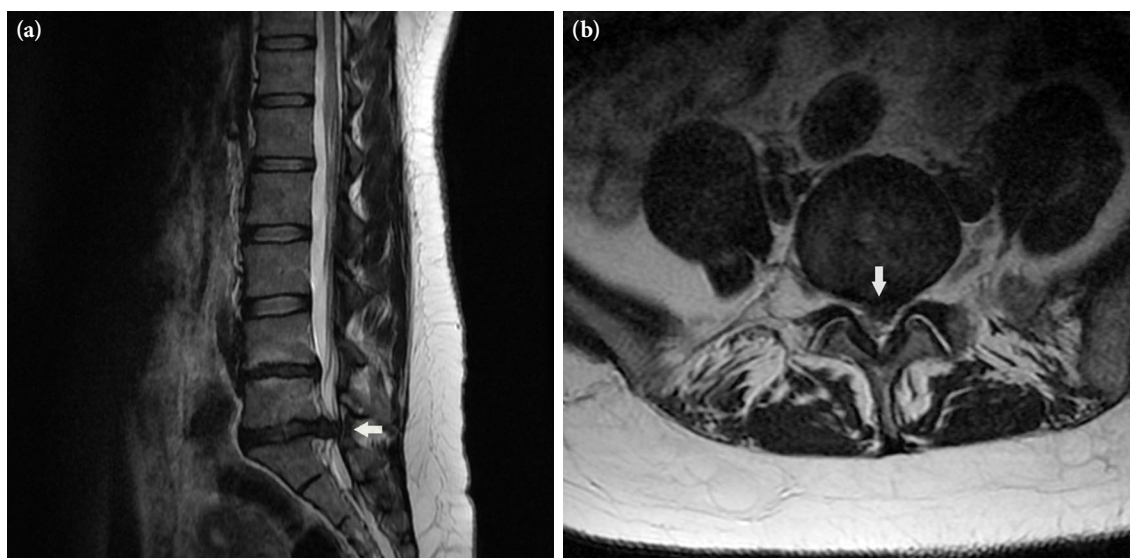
(a) Central disc extrusion (white arrows) at the L5-S1 level in the sagittal and (b) axial planes of magnetic resonance imaging of the lumbar spine.
